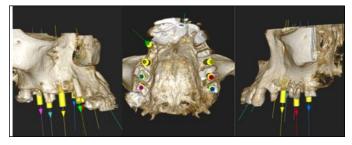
Implant planning on CBCT Implant placement
